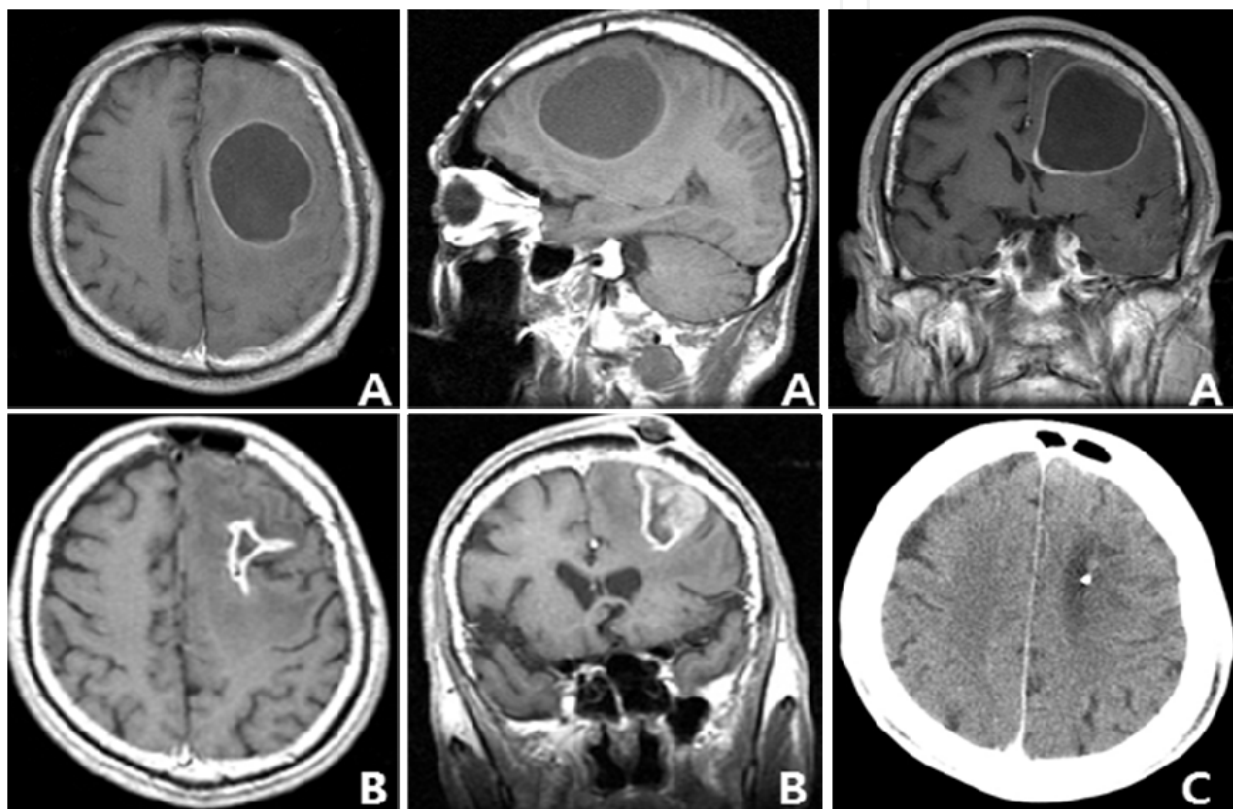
Gadolinium-enhanced T1-weighted MR image of a 63-year-old man with a large cystic brain metastasis developing from non small cell lung cancer. A : Before aspiration : initial cyst volume, 36.0 cc. B : After cyst aspiration, volume, 8.0 cc. The prescription dose was 20 Gy. C : Enhanced CT scan obtained 6 months postradiosurgery showing no definite enhancing tumor.
